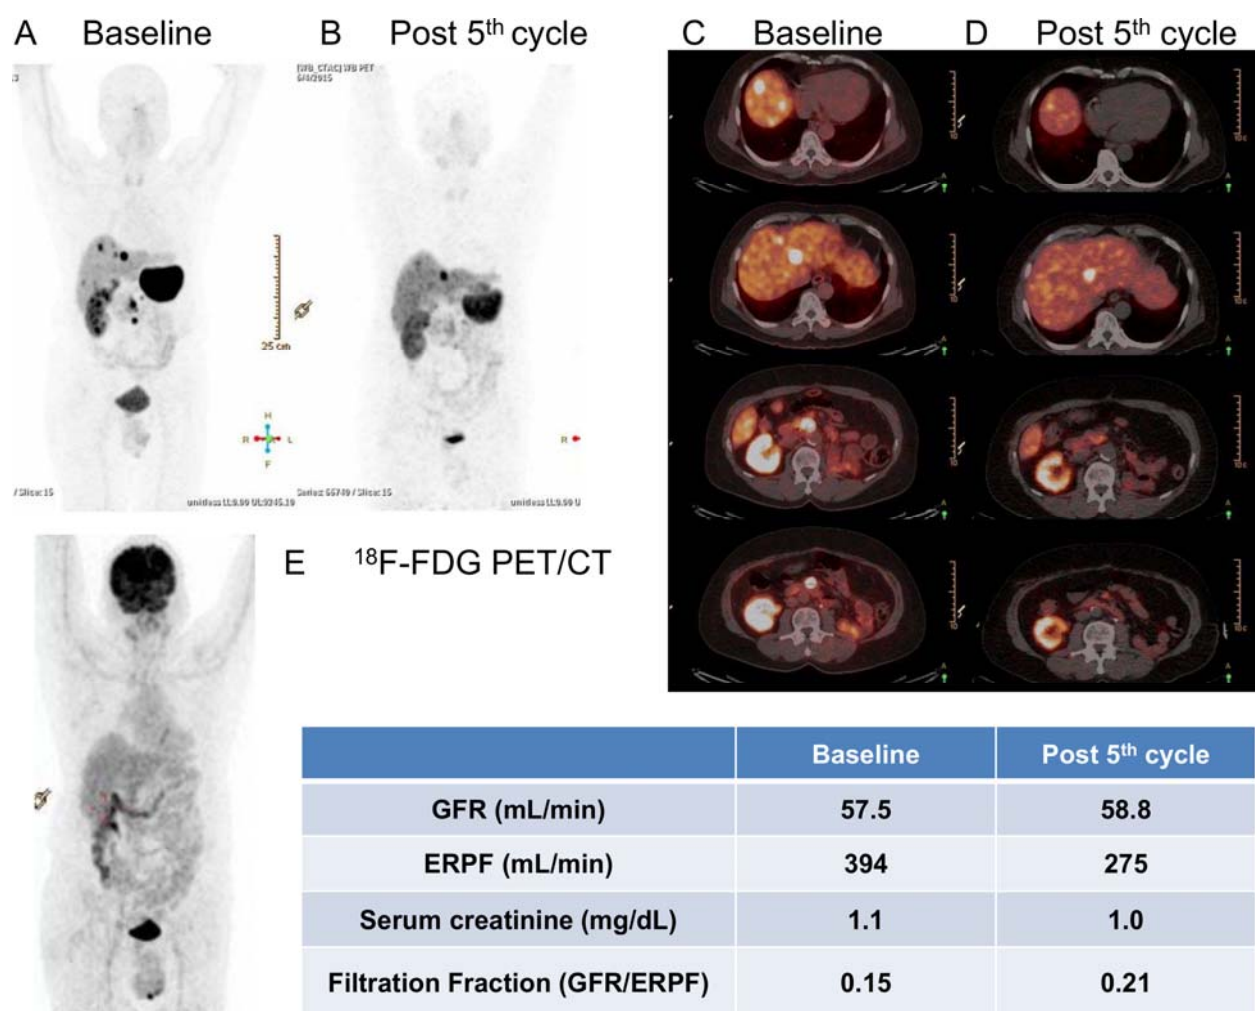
62 year old male, who initially presented with abdominal pain and had a CT scan documented mesenteric mass which following excision was found to be well differentiated NET on HPR. The patient also had history of renal cell carcinoma of left kidney and had undergone left nephrectomy. After a disease free period of 4 years, the patient present with disease recurrence with ^{68}Ga -DOTATATE PET/CT showing SSTR expressing lesions in segment IV and segment VIII with few peripancreatic nodules (Fig 1A and 1C). ^{18}F -FDG PET/CT was normal (Fig 1E). The patient has undergone 5 cycles of ^{177}Lu based PRRT. Post 5th cycle PRRT ^{68}Ga -DOTATATE PET/CT (Fig 1B and 1D) showed almost complete resolution of seg VIII and peripancreatic lesions with only seg IV lesion seen. Overall treatment response assessment was good partial response.
